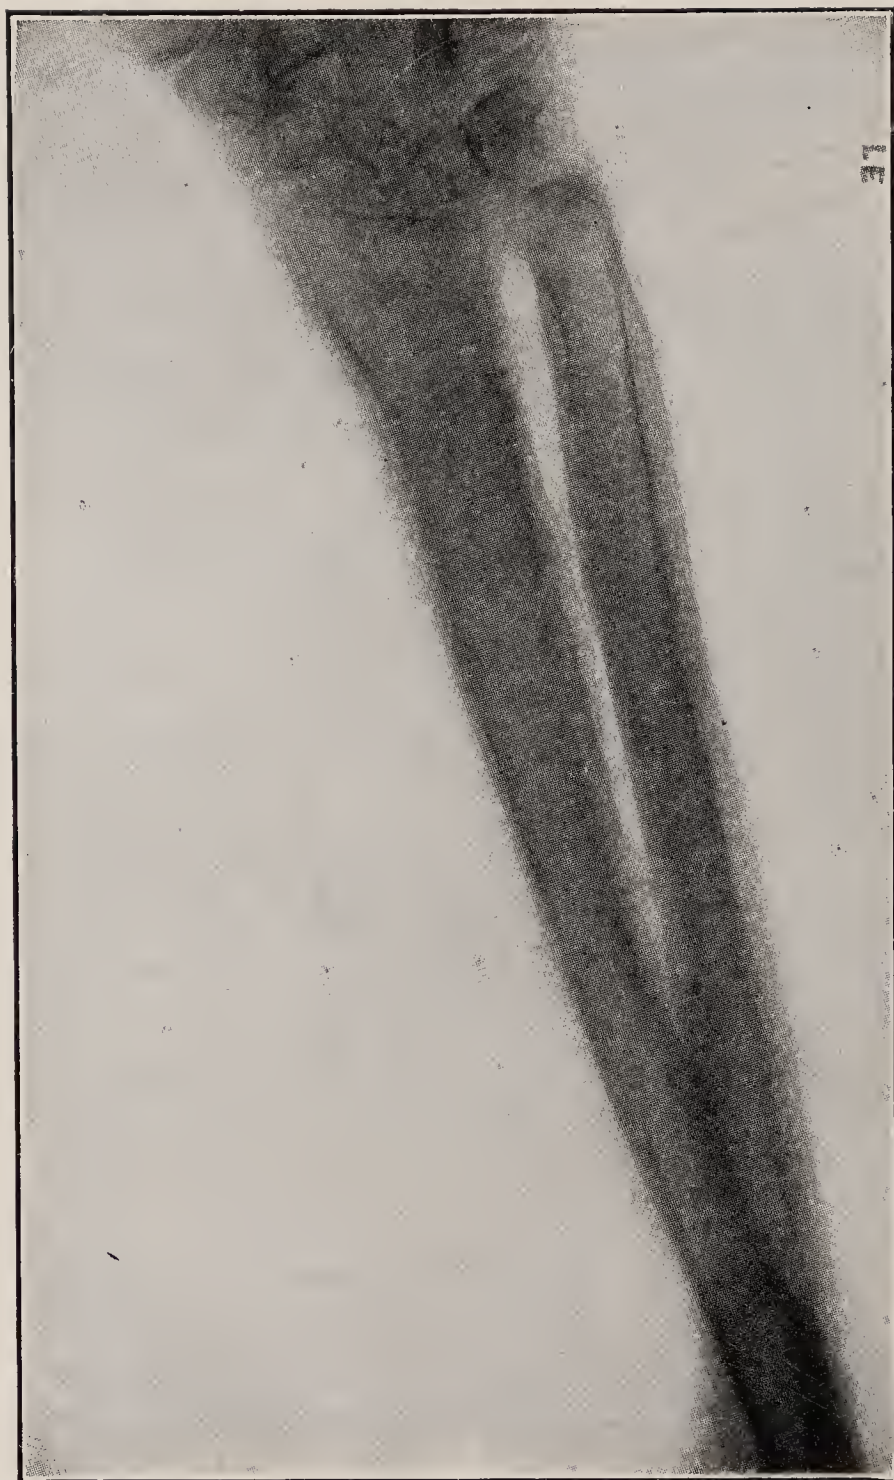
Secondary hypertrophic osteo-arthritis—adult male forearm, X-ray showing characteristic irregular subperiosteal layer of new bone, especially abundant about epiphyses (E. A. Locke).
